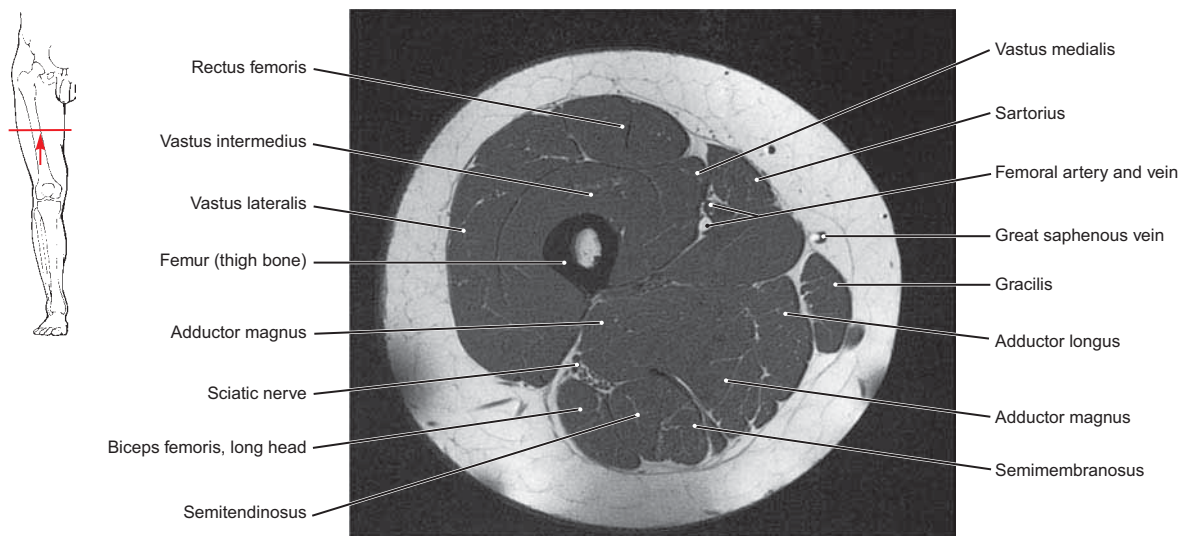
MRI Near the Middle of the Right Thigh
